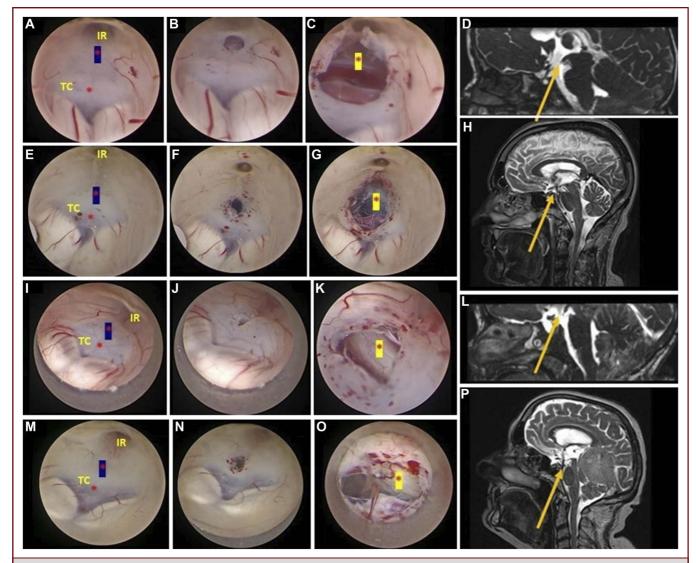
ETV with diminished PPI in other contexts. A-D, Pediatric patient with diminished PPI and obstructive hydrocephalus due to posterior fossa rupture arteriovenous malformation lesion. The main determinant is the incomplete formation of the dorsum sellae due to the patient's age. In this case, our direction should be directed toward the posterior aspect of the clivus to avoid entering the sella turcica. E-H, The patient with obstructive hydrocephalus in the context of shunt malfunction, presenting a diminished PPI. In this case, the limiting factor is the opacity of the tuber, which does not allow clear identification of the dorsum. By using the techniques described in the article, we can safely perform ETV. I-L, Pediatric patient with decreased PPI due to a posterior fossa tumor causing obstructive hydrocephalus. M-P, The patient with space-occupying lesion in the pineal cistern leading to a decrease in PPI and obstructive hydrocephalus. In all of them, the red asterisk on the blue background marks our entry zone. The red asterisk marks the entry zone in a classic ETV. The red asterisk on the yellow background marks the dorsum sellae. In addition, postoperative MRI control is provided, demonstrating ostomy patency. ETV, endoscopic third ventriculostomy; PPI, prepontine interval; TC, tuber cinereum.
